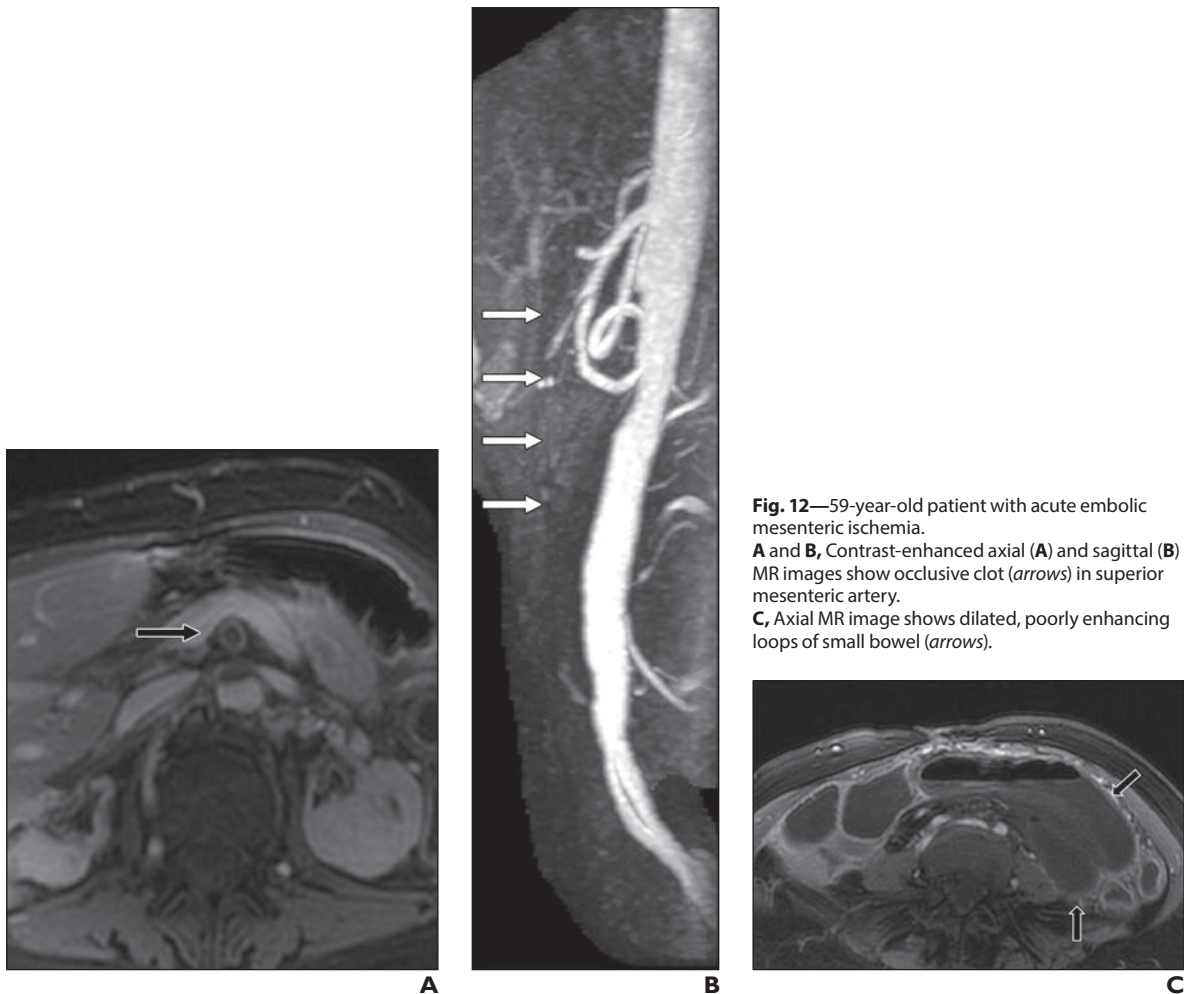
59-year-old patient with acute embolic mesenteric ischemia. A and B, Contrast-enhanced axial (A) and sagittal (B) MR images show occlusive clot (*arrows*) in superior mesenteric artery. C, Axial MR image shows dilated, poorly enhancing loops of small bowel (*arrows*).
